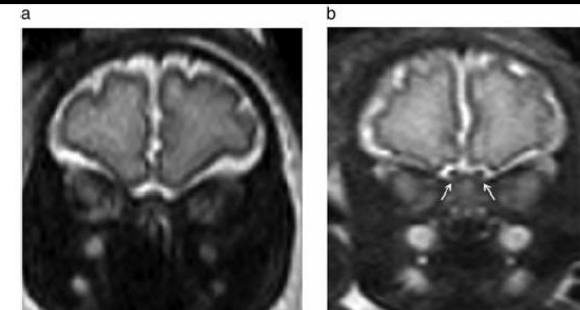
Arhinencephaly prenatal magnetic resonance imaging at 32 weeks of gestation: coronal T2-weighted sequences. a: Absence of the olfactory bulbs. b: Normal fetus for comparison: normal aspect of the olfactory bulbs (arrows)
